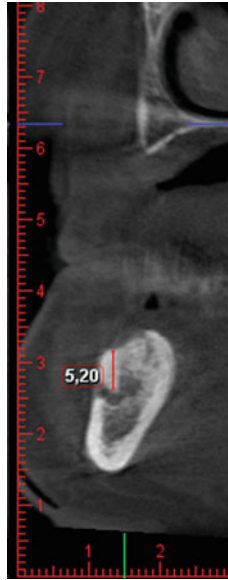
CBCT cross-section showing the measurement from the roof of the mandibular canal to the alveolar crest
